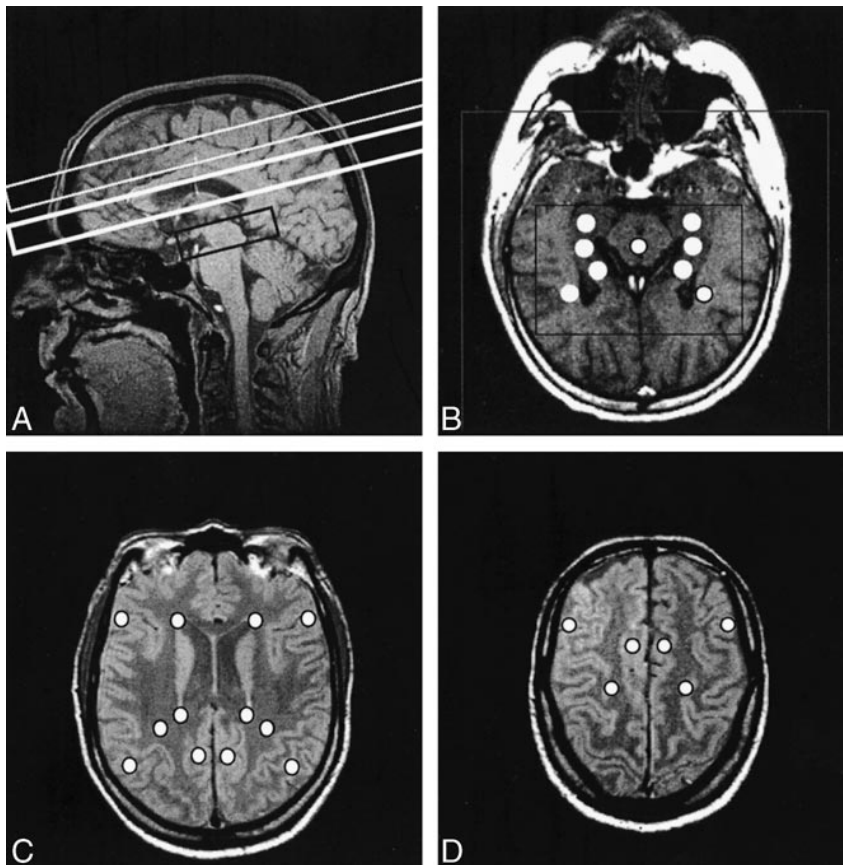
Various MR images are shown for comparison.
